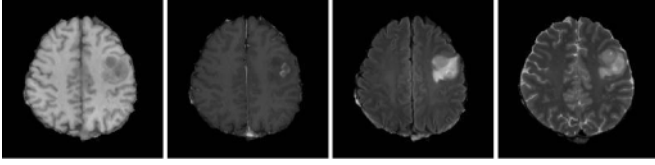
Imaging profile of a glioma; from left to right: T1, Contrast enhanced T1, FLAIR and T2 images.
